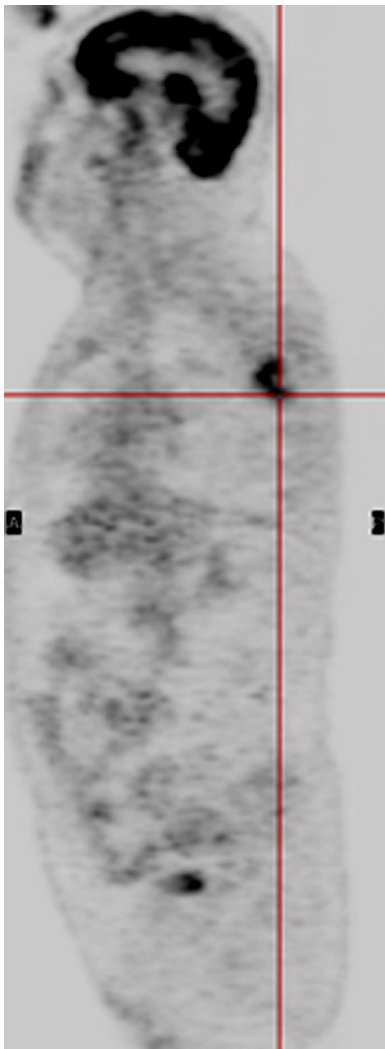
Lateral fludeoxyglucose (^{18}F) positron emission tomography (^{18}F -FDG PET) performed after the first surgery shows FDG uptake at T5 with no evidence of systemic disease.
